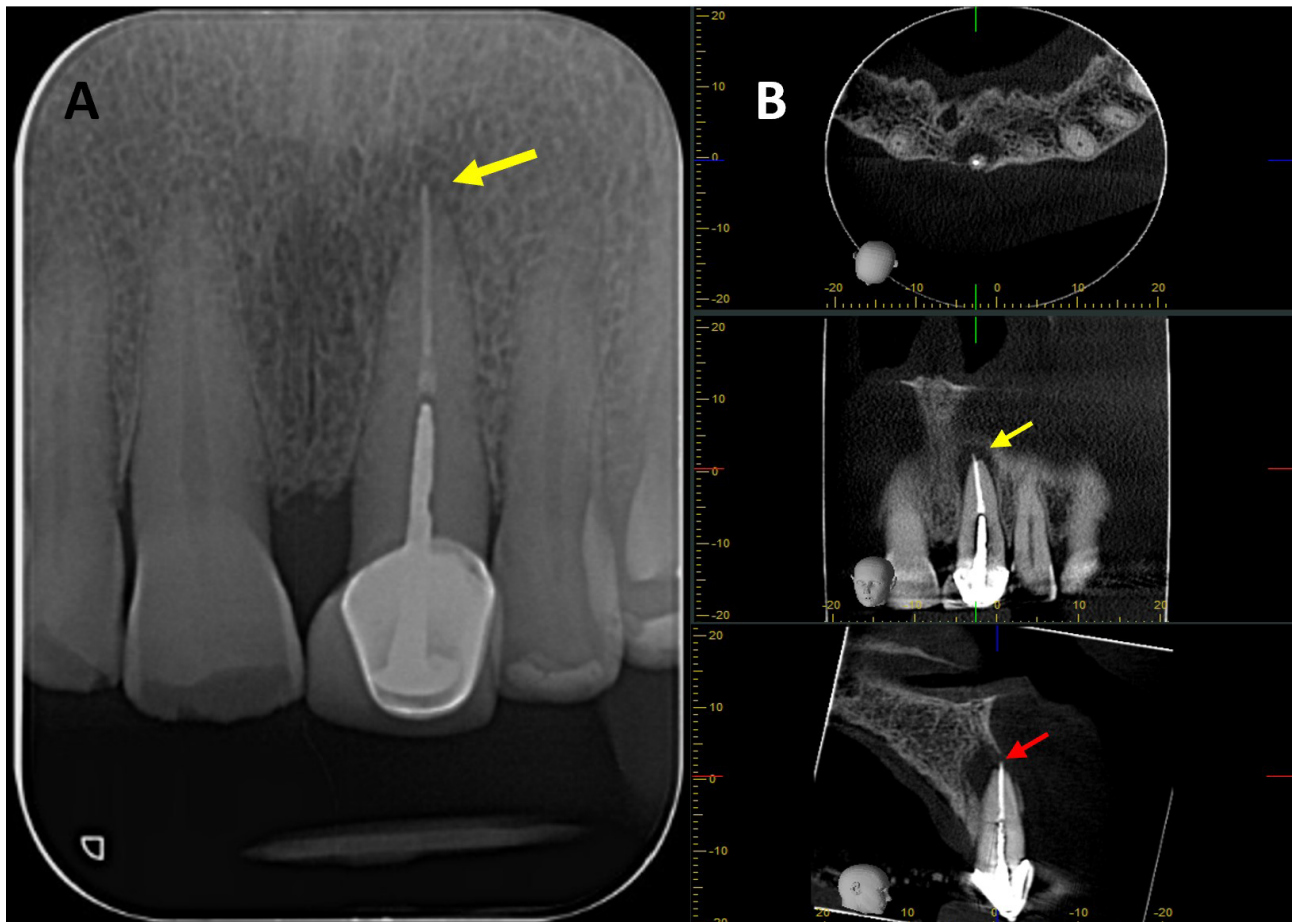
(A) Preoperative periapical radiograph of tooth #21, which the presence of a periapical radiolucency is not clearly. (B) Preoperative CBCT of tooth #21, presented in axial, coronal, and sagittal sections, reveals a hypodense area at the apical region consistent with a periapical lesion. The sagittal section demonstrates vestibular bone fenestration, as indicated by the *red arrow*. The *yellow arrow* denotes the presence of transapical obturation material in both the periapical radiograph and CBCT, as well as the existence of a post and prosthetic crown.
